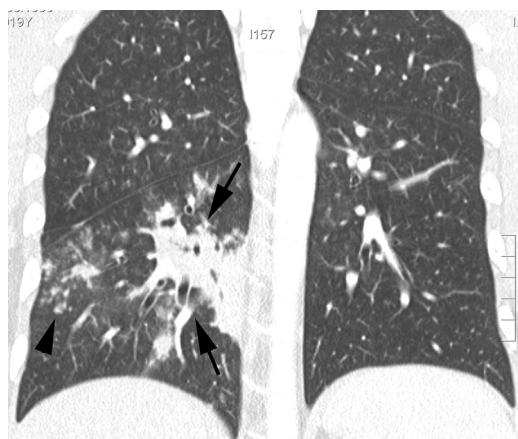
Bronchopneumonia caused by *Haemophilus influenzae*. Coronal reformatted CT shows a focal area of consolidation in the right lower lobe with visible air bronchogram and poorly defined margins (arrows). Also evident are small nodular opacities and a few tree-in-bud opacities (arrowhead).
